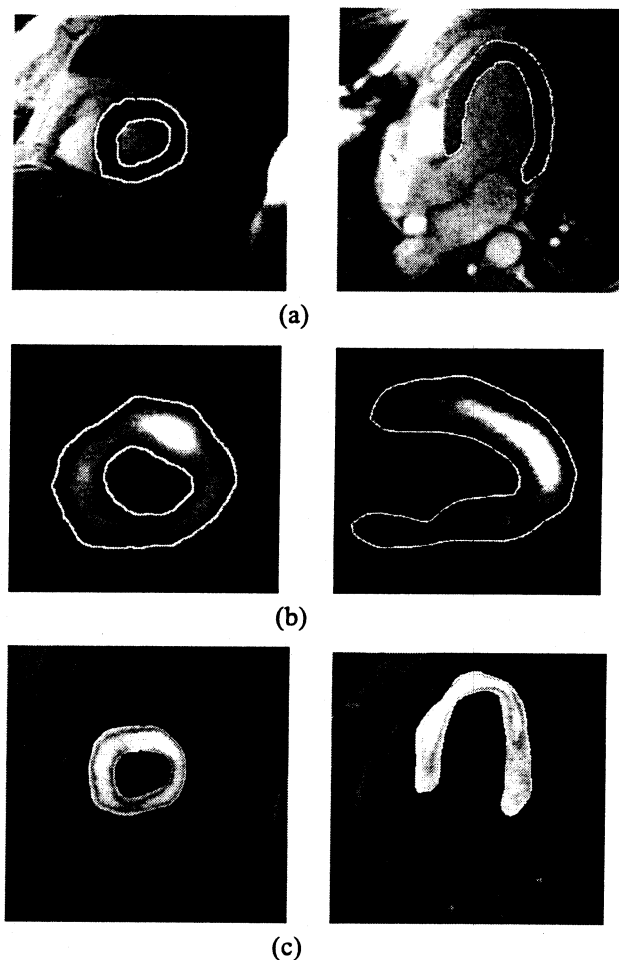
results relevant to a pathologic heart; left side: short axis view; right side: long axis view; (a): MRI (b): SPECT; (c): resulting fused images
